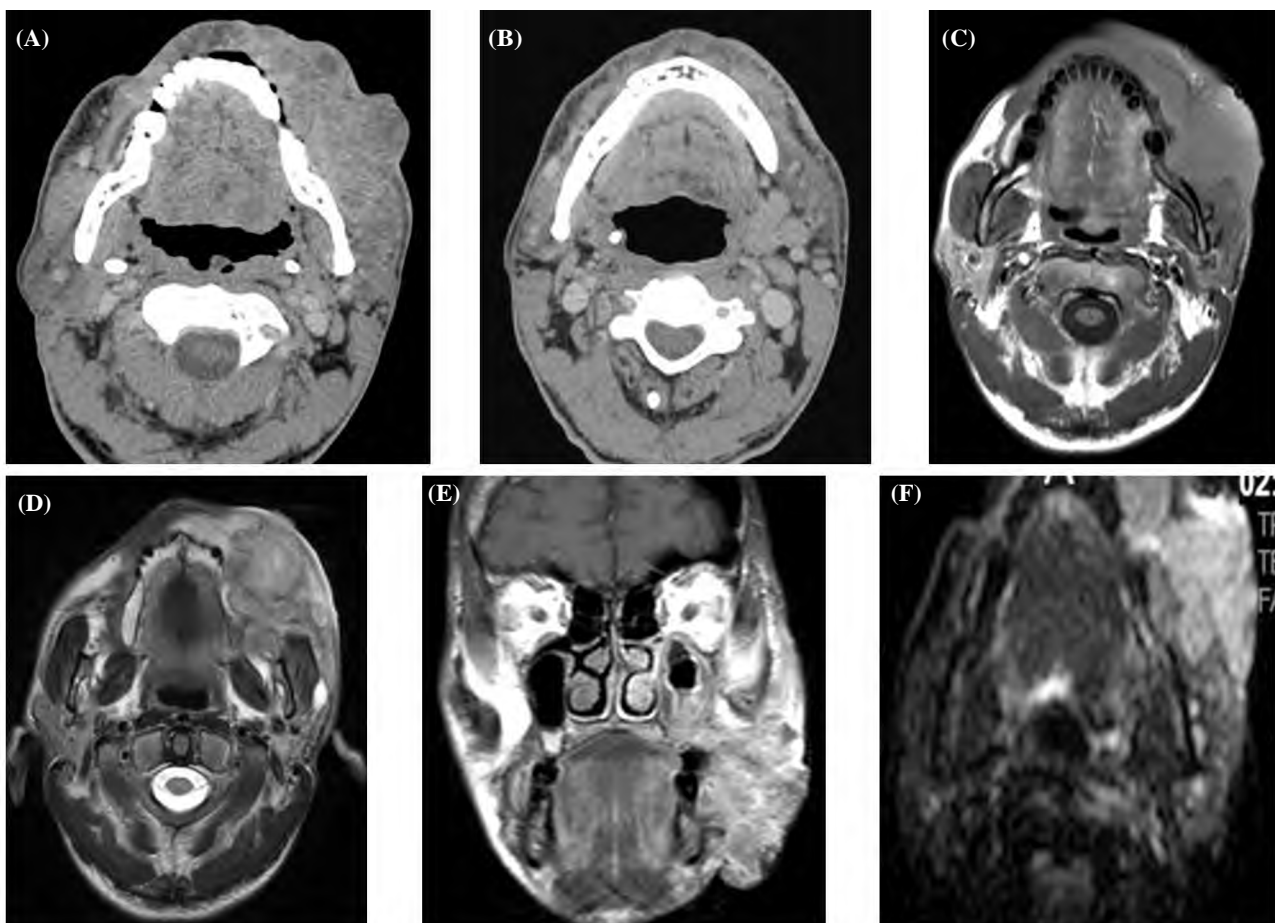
A and B axial CT scan of the maxillofacial for 58 old male show, left buccal soft tissue ill-defined ulcerating mass lesion with central breakdown, it shows inhomogeneous contrast uptake and destruction of the underlying maxillary bone with bilateral enlarged lymph node. MRI (T1 (C)) & T2 (D) & post contrast T1 (E) images and ADC (F)) showing low T1, high T2 and inhomogeneous contrast uptake, with bone marrow affection, it shows restricted diffusion, Pathology: SCC (squamous cell carcinoma).
